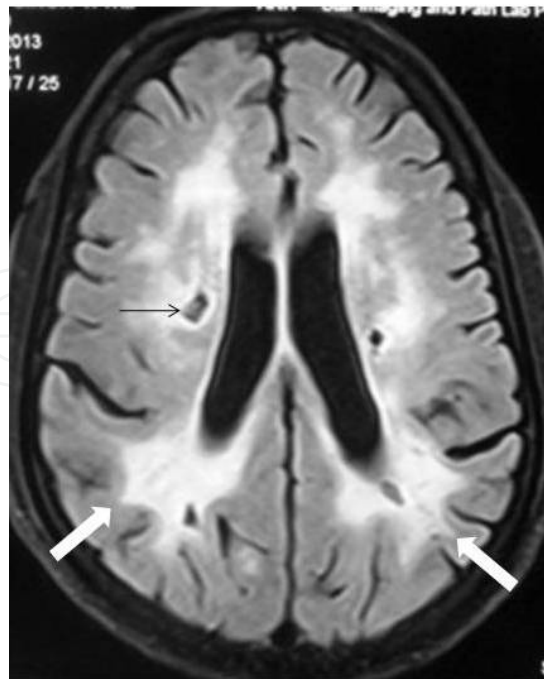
Axial MRI (FLAIR sequence) of the same patient as in figure 2, demonstrates bilateral symmetrical, confluent, supratentorial periventricular white matter hyperintensity with involvement of posterior subcortical U fibers (thick arrows). Also note dilated perivascular spaces (Virchow Robin spaces) in deep cerebral white matter (thin arrow).
